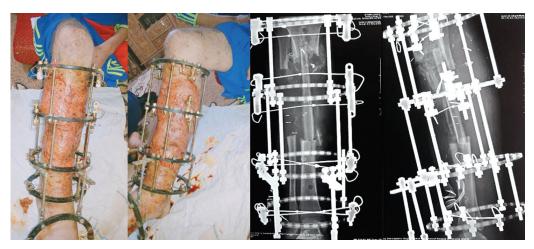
Postoperative clinical appearance and radiographs of tibia
